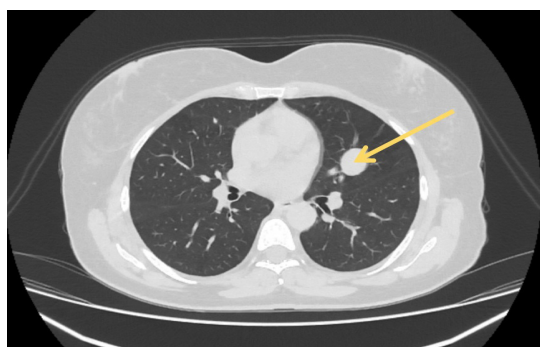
Evidence of a tumoral lesion in the left paracardial (lingual) region identified on a contrast-enhanced computed tomography (CT) scan.
